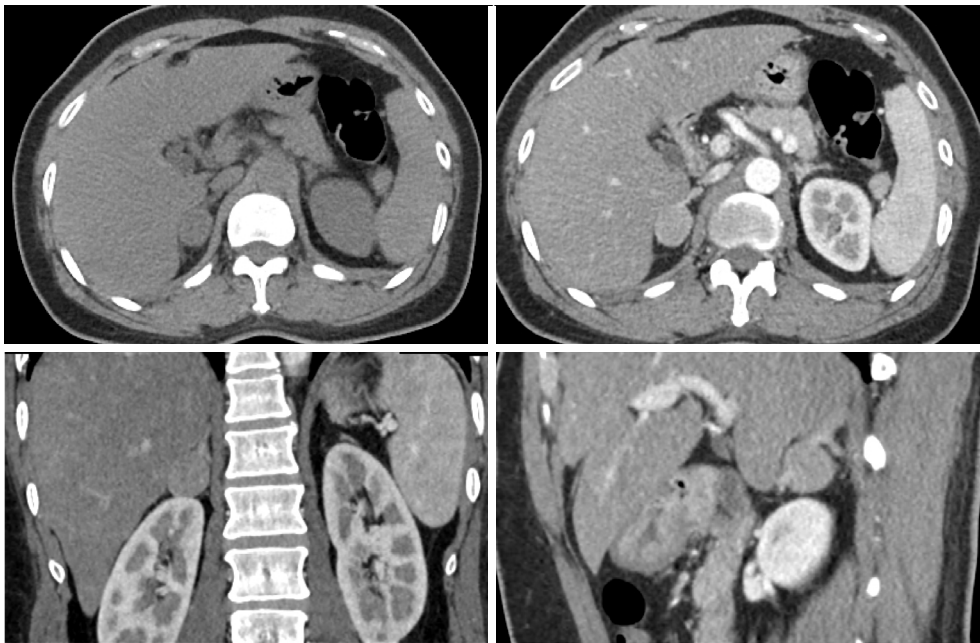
An example of a patient with right-sided nonfunctional adenoma. The scores of each indicator were as follows: tumor size, 1; relationship of the tumor with the upper poles of the kidney and the renal hila, 1; the adhesion of PF, 2; relationship of the tumor with abdominal large blood vessels, 1; tumor CT enhancement value, 1; relationship of the tumor with surrounding organs and tissues, 1; and functional status of adrenal tumors, 1. This patient's score was calculated as follows: $0.1473 \times 1 + 0.1264 \times 1 + 0.1379 \times 2 + 0.1662 \times 1 + 0.0291 \times 1 + 0.2147 \times 1 + 0.1784 \times 1 = 1.1379$. The values of the indicators were as follows: OT, 30 minutes; IBL, 30 mL; and grade II (moderate complexity and difficulty). PF, periadrenal fat; CT, computed tomography; OT, operative time; IBL, intraoperative blood loss.
